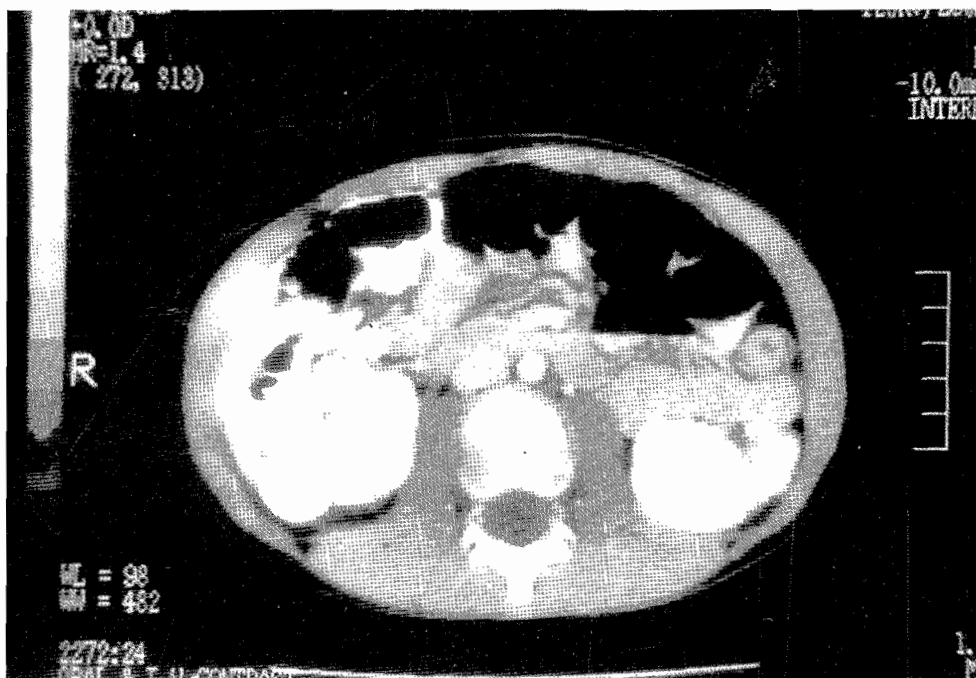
Follow-up CT of the same patient 3 months after renorrhaphy showing a normal right kidney
